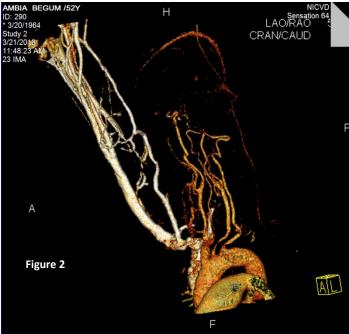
and 2 showing CT angiogram featuring arterial changes.
